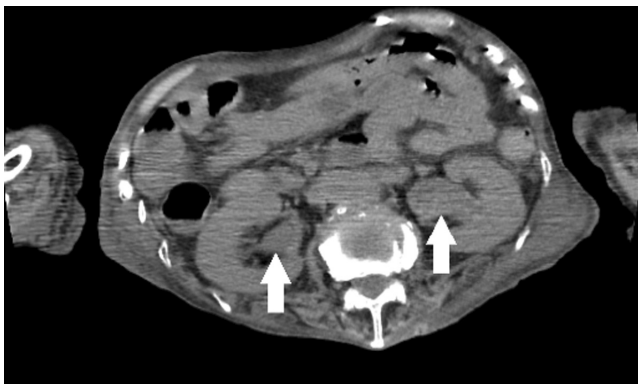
CT revealing bladder wall thickening, full-length dilation of bilateral ureters, and bilateral hydronephrosis (white arrow).
